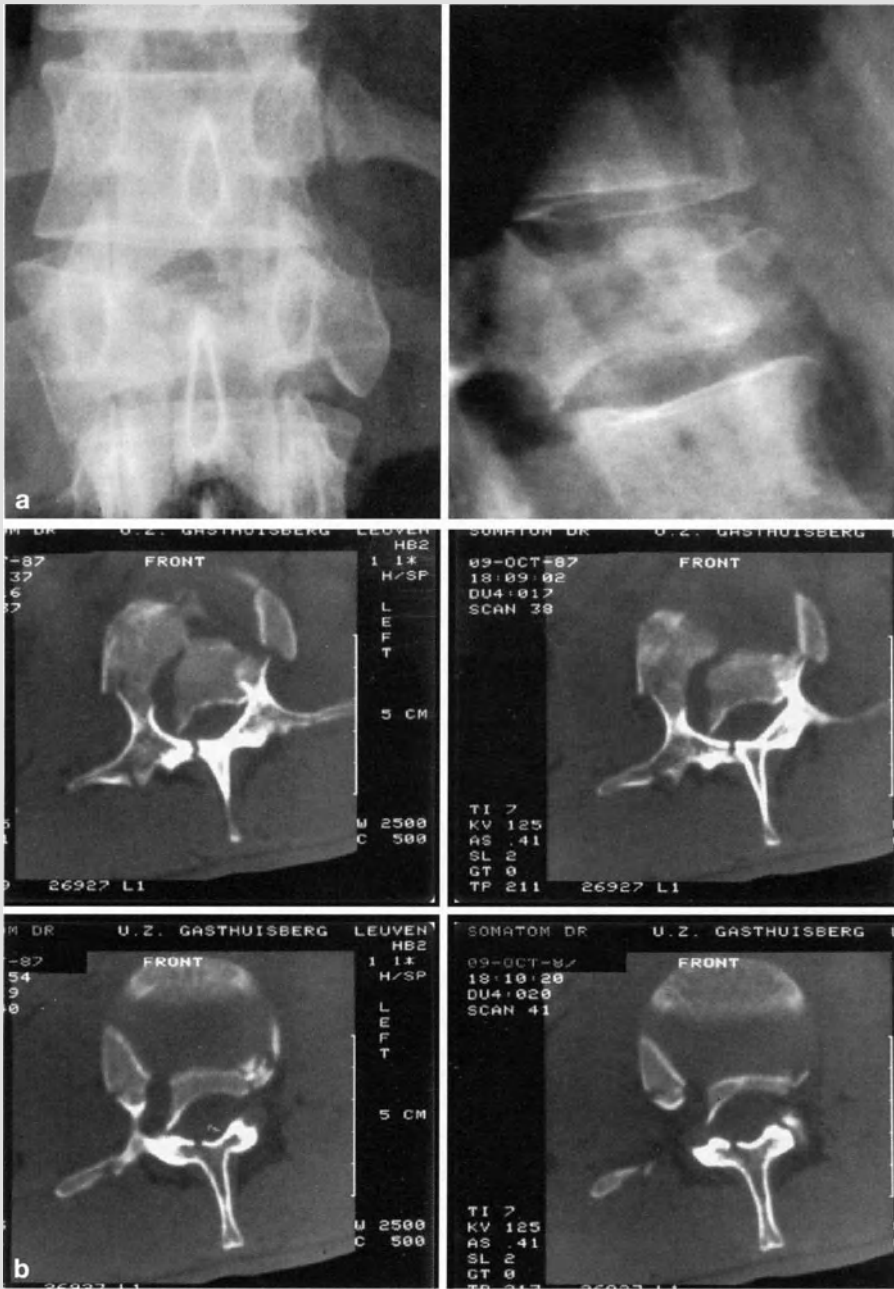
a Burst fracture of L1 in a 27-year-old man after a motor vehicle accident. Note the decreased height and the broadening of the vertebral body on AP and lateral views, the vertical gap in the vertebral body on the AP view, and the protrusion in the spinal canal of the fractured posterior aspect of the vertebral body in the lateral view. b CT of the same level show a nearly complete obstruction of the spinal canal
